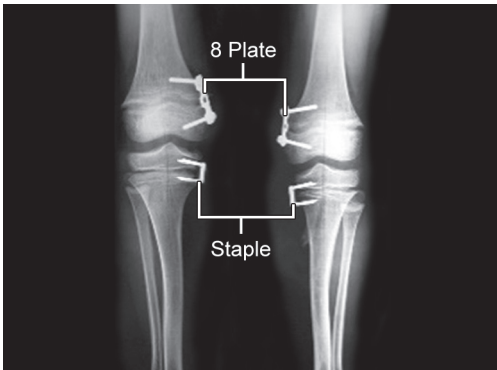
X-ray: Epiphysiodesis around knee fixed with figure 8 plate and Blounts' staple
